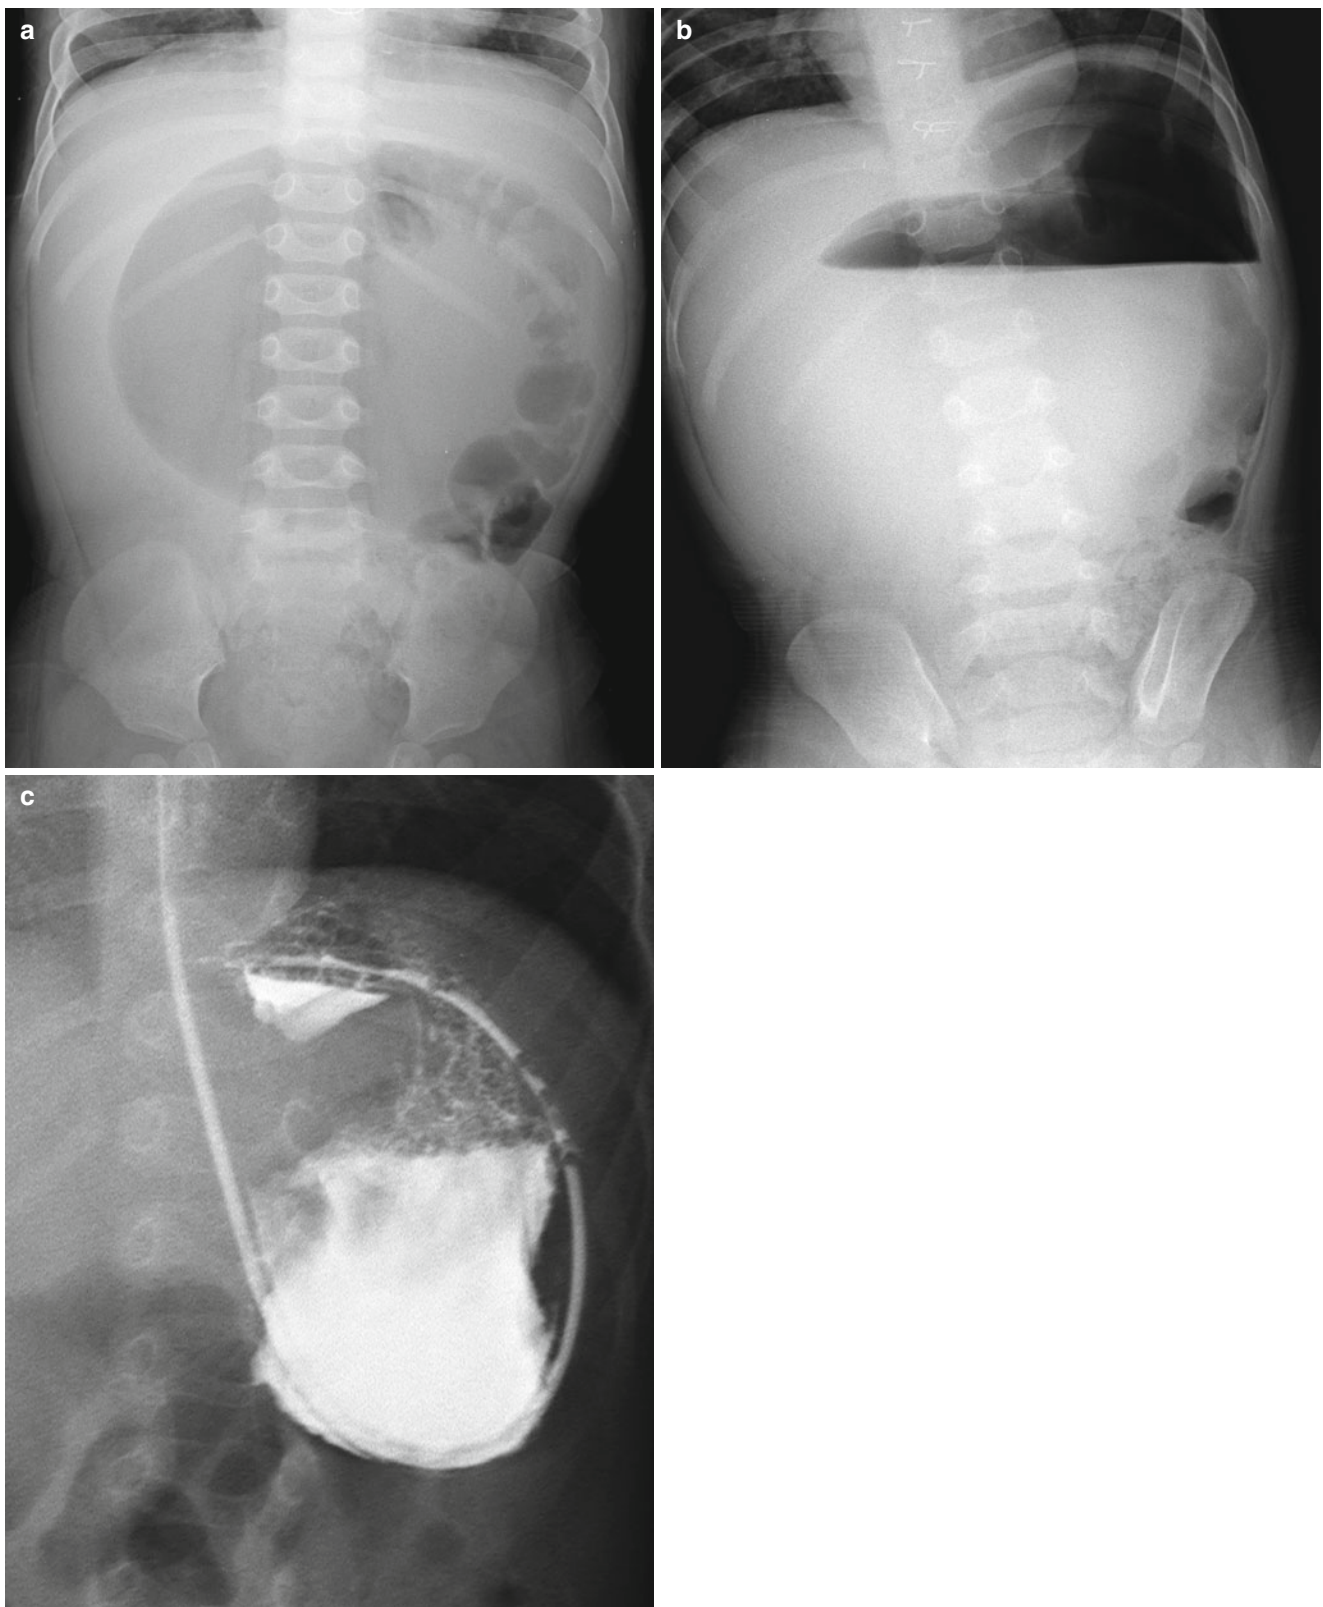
Mesenteroaxial volvulus in a 11-month-old girl with abdominal distension and vomiting. Supine (a) and erect (b) abdominal radiographs show a marked spherical distension of the stomach with two air-fluid levels. Note sternal wirings by previous surgery for congenital heart disease. (c) Image from UGI study after gastric decompression
